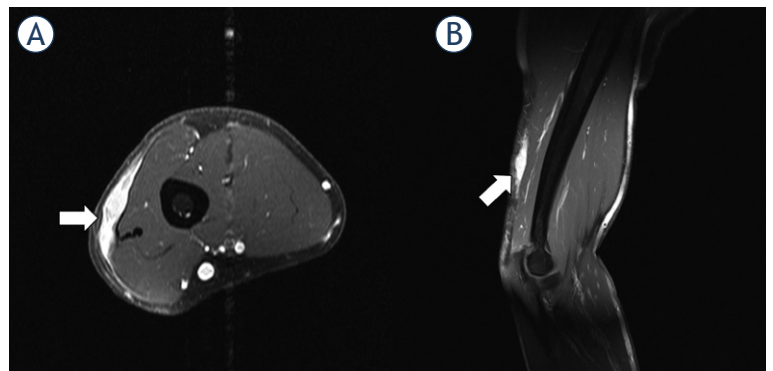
1.5-T MRI of the upper arm (A) contrast-enhanced T1 axial, (B) contrast-enhanced T1 sagittal) of a 48-year-old patient. The higher-grade sarcoma in the subcutaneous tissue (white arrow) has a streaky configuration and shows slight infiltration of the surrounding subcutaneous tissue.
